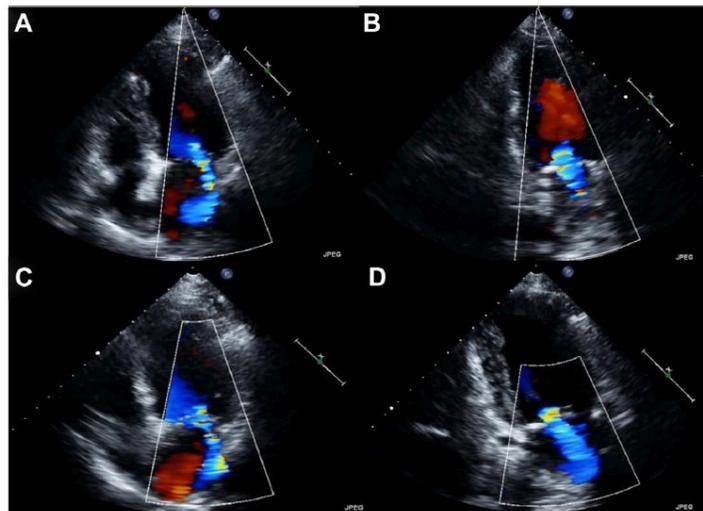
Transthoracic Echocardiographic Images of Mitral Regurgitation Pre- and Post-Transcatheter Aortic Valve Replacement (Patient With Organic Mitral Regurgitation)
